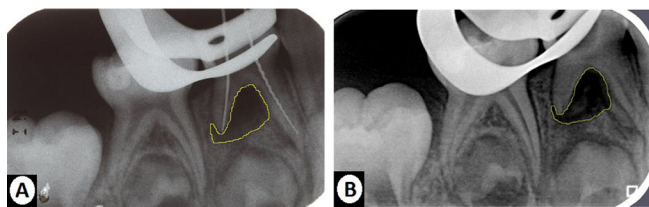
Radiographic images showing the measurement of periapical lesions in Image J software. A) conventional radiograph; B) digital radiograph
